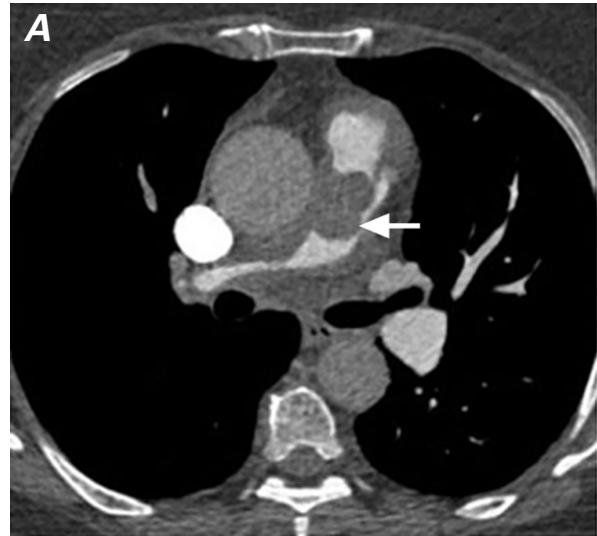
Computed tomograms appear to show A) a pulmonary embolism (arrow) and B) endoluminal thromboemboli extending from the pulmonary valve (black arrow) into the right and left pulmonary arteries (white arrows).
